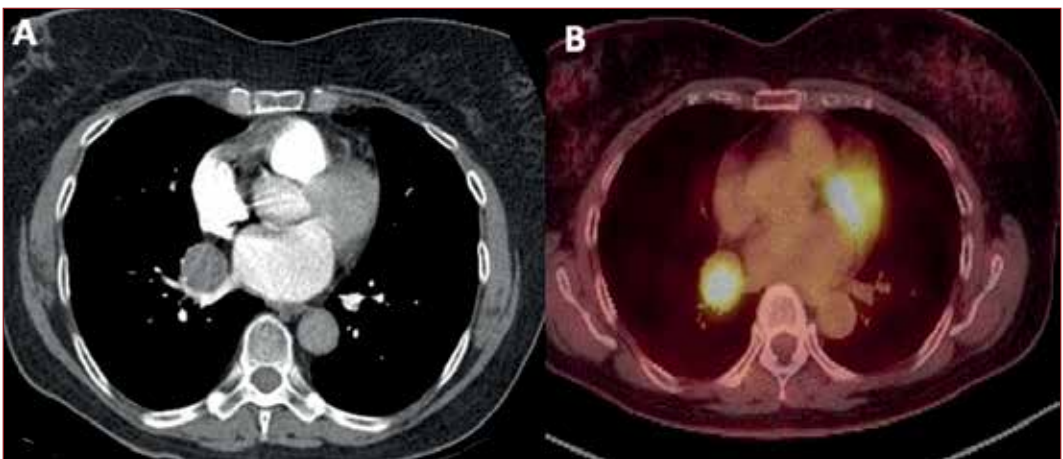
A CT scan and B PET scan demonstrating right lower lobe carcinoid tumour.
